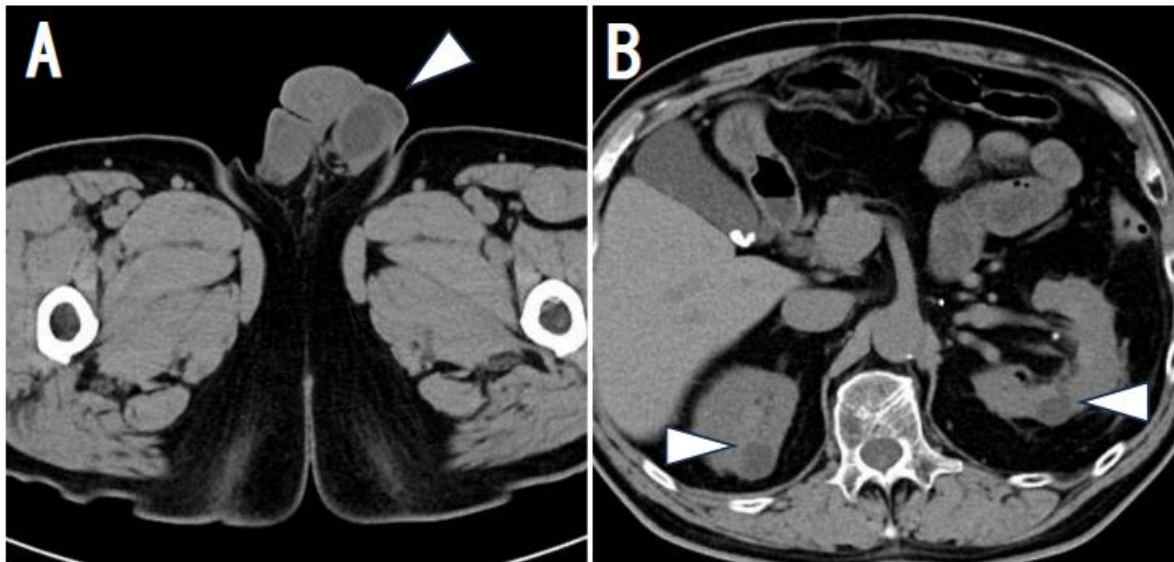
CT images. (A) Pelvic CT showing a 3-cm intratesticular cyst in the left testis with a small hydrocele (arrowhead). The additional multilocular cysts were not clearly visualized on CT. (B) Abdominal CT showing simple renal cysts in both kidneys (arrowheads). No retroperitoneal lymphadenopathy is present.
